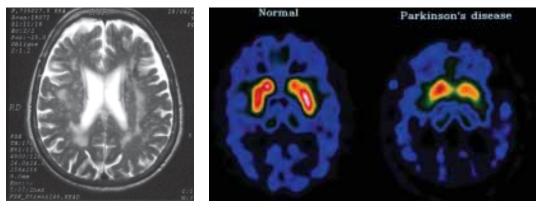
MRI of Parkinsons Disease
